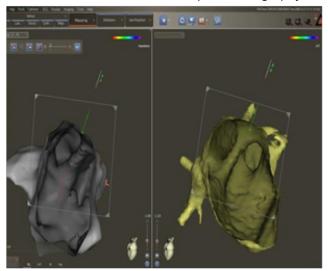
Merge between the electroanatomical map (left side) and computed tomography (right side). Images are very similar in terms of anatomy of left veins and ridge between the veins.
